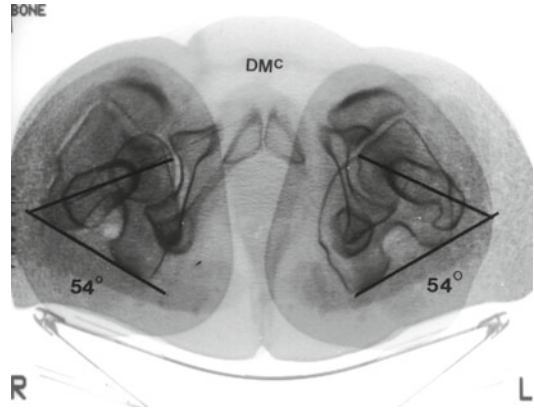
Preop CT rotational scan shows bilateral 54° femoral anteversion
